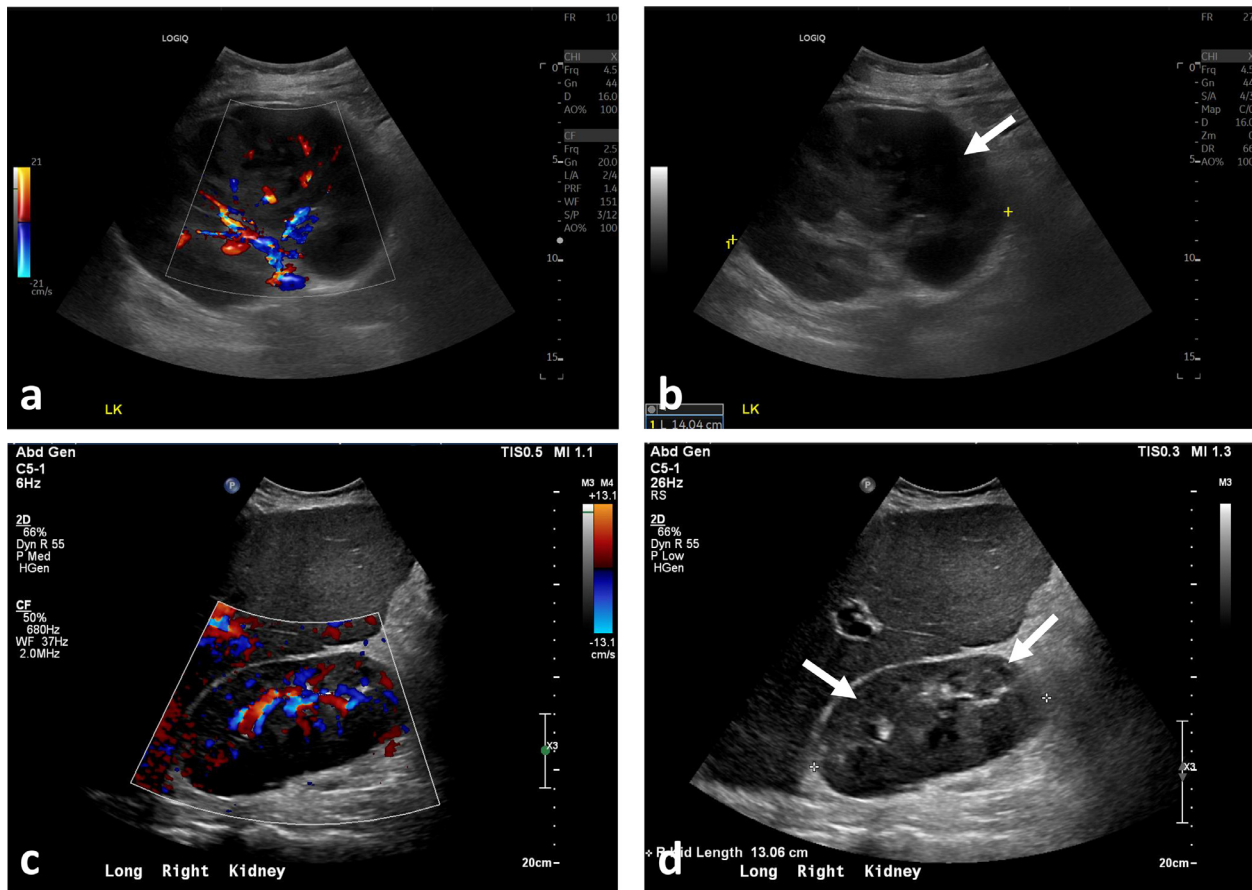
Ultrasound images of the left kidney (a, b) obtained at the time of renal biopsy and right kidney (c, d) at the time of right upper quadrant ultrasound demonstrate left greater than right nephromegaly with heterogeneous echogenicity of the renal parenchyma and scattered hypoechoic foci (arrows) consistent with abscesses. Heterogeneous renal perfusion is also present on color Doppler images (a, c).
